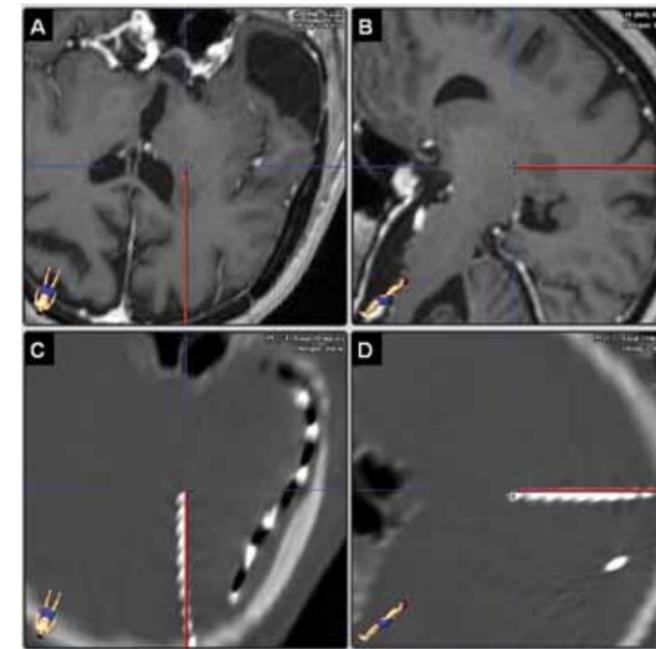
Example of comparison of preoperative planned trajectory (red line) to a deep heterotopia on (A, B) preoperative magnetic resonance imaging and (C, D) postoperative computed tomography. Electrode placement was accurate to within 1 millimeter of the preoperative plan.
